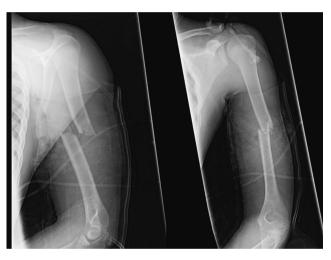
(a-b): Left humerus plain film radiographs on initial presentation.
